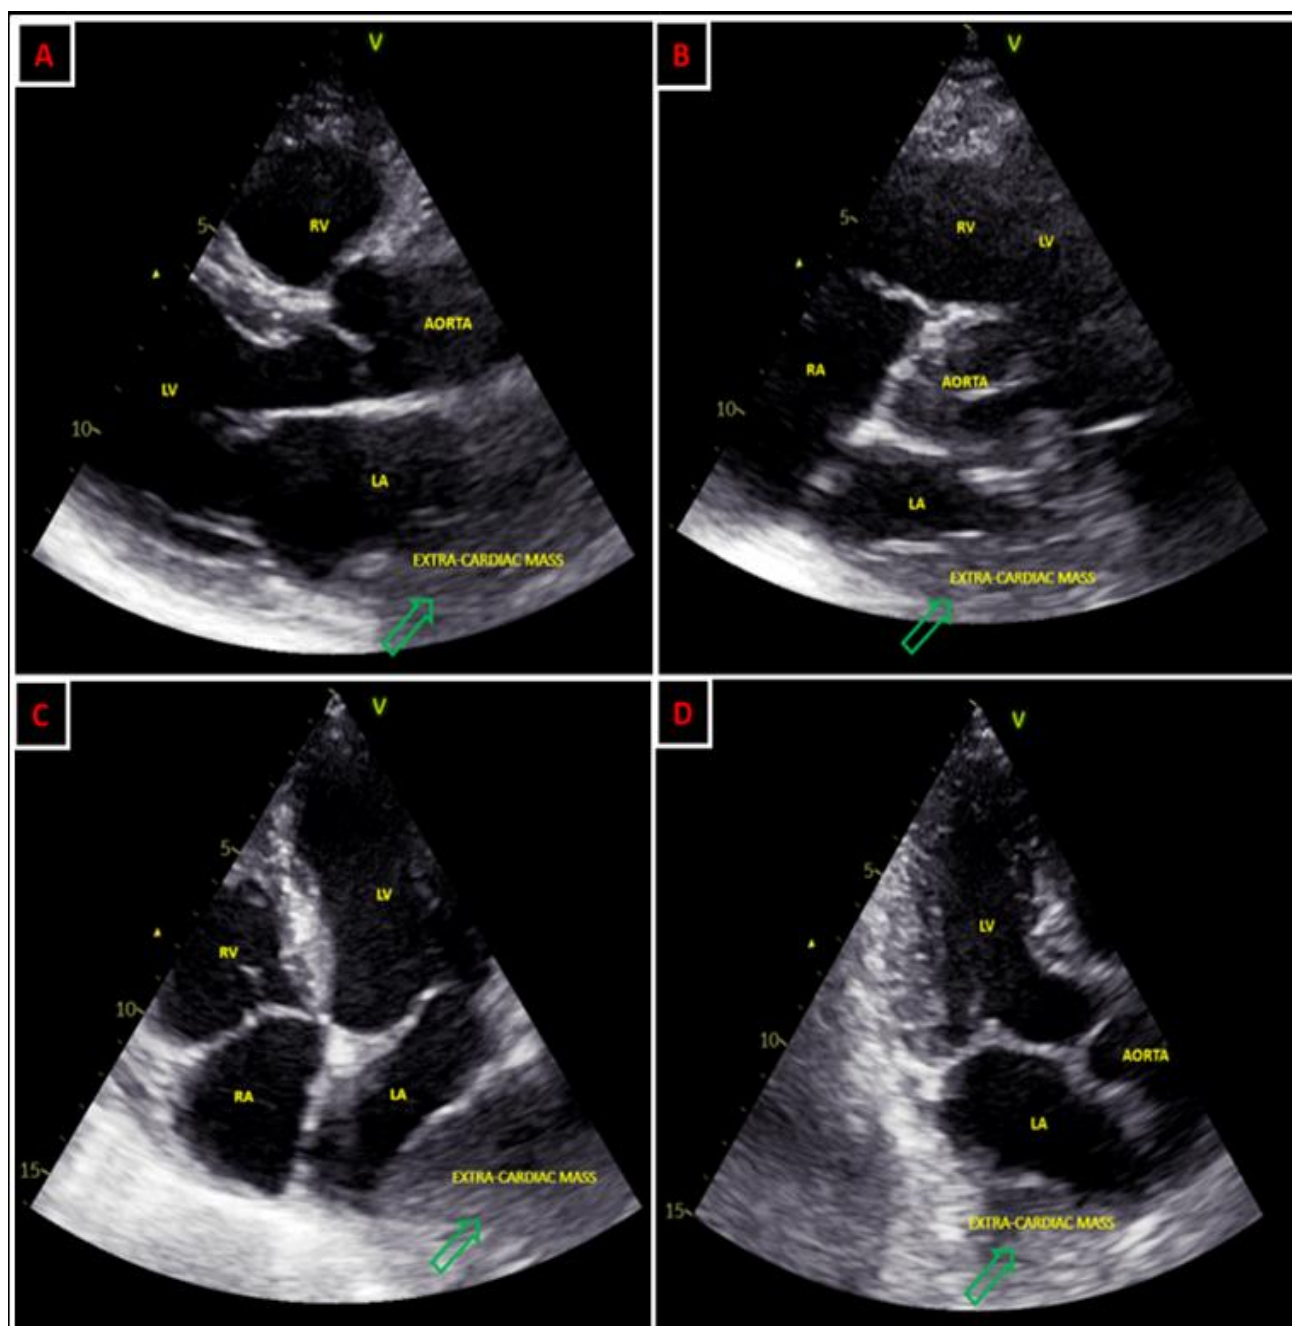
Transthoracic echocardiography images demonstrating extrinsic compression of the left atrium by a heterogeneous extra-cardiac mass assessed in the parasternal long-axis (A), parasternal short-axis (B), apical four-chamber (C), and apical three-chamber views (D)
